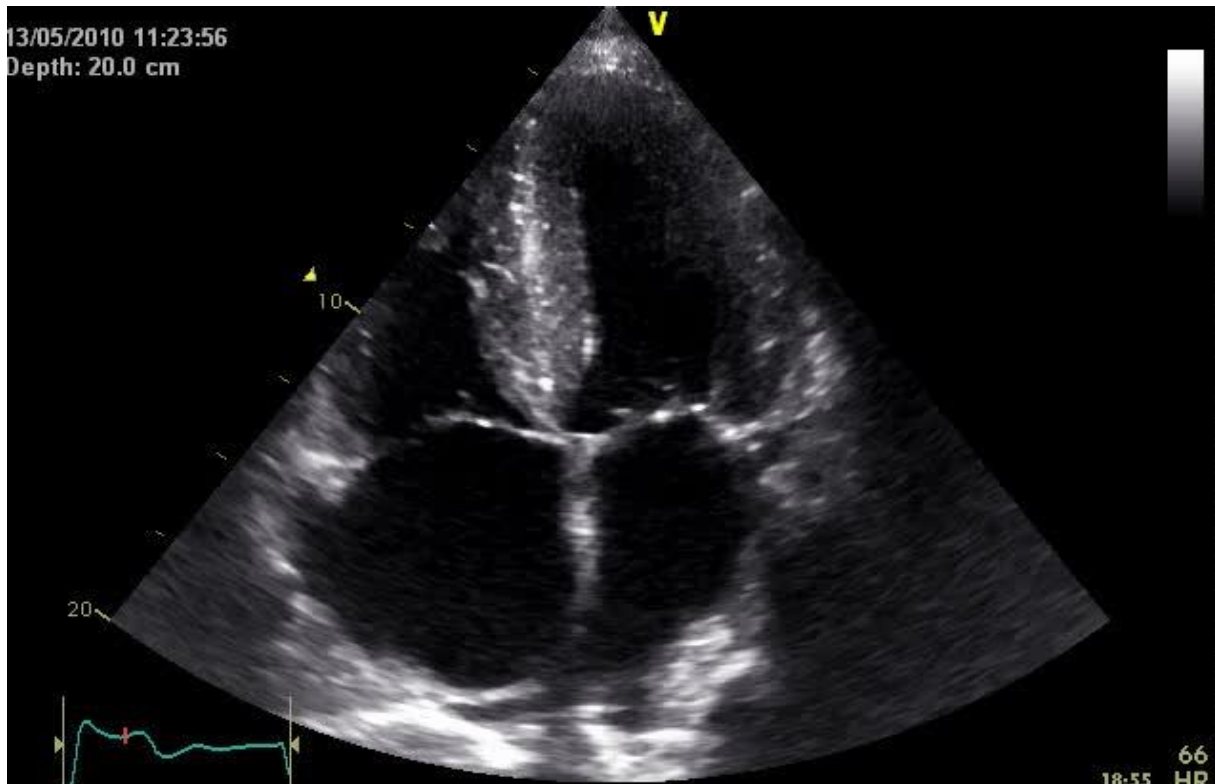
Echocardiogram for Hypertrophic Cardiomyopathy [19]
